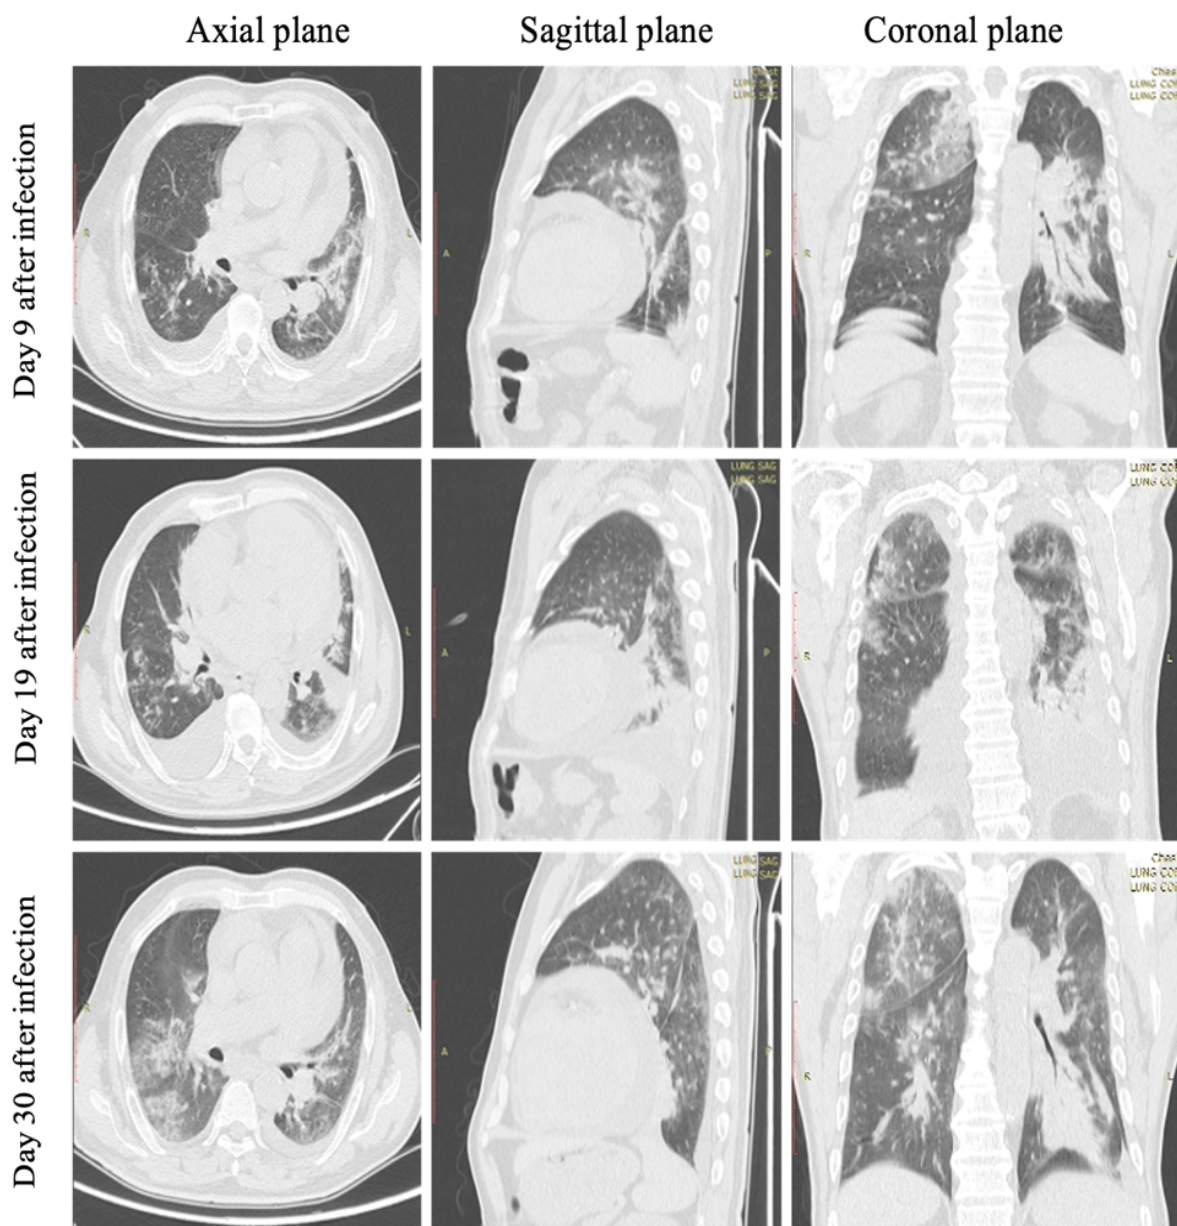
CT scan of case 4. On day 9 after infection, CT scan showed that there was mixed density consolidation on the ground glass opacity in the upper lobe of the right lung, the upper and lower lobes of the left lung. Pleural effusion was present and lymph nodes were enlarged to 1.6cm. On day 19, lesions started to be resolved and density of other changes was increased. Ground glass opacity, symptom reversed halo sign, air-bronchogram sign, and pleural effusion are the signs for disease severity. After 30 days, changes were resolved, and density was decreased in upper and lower lobes of the lungs.
